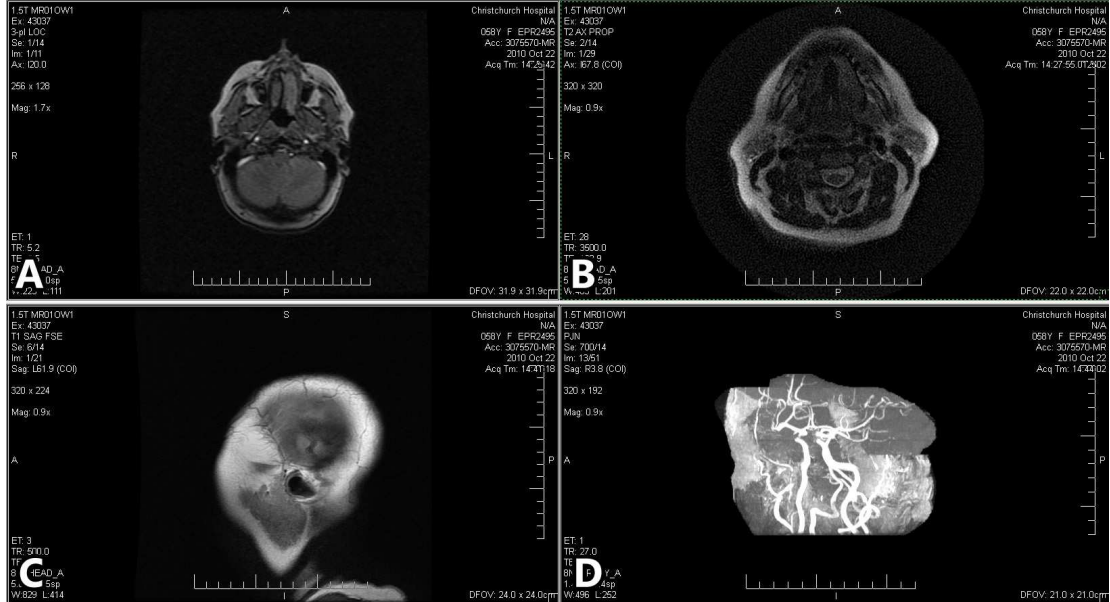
Visualisation of an MRI dataset with eFilmLite [63]. Different 2D views (A, B and C) are shown along with a basic 3D rendering (D).
